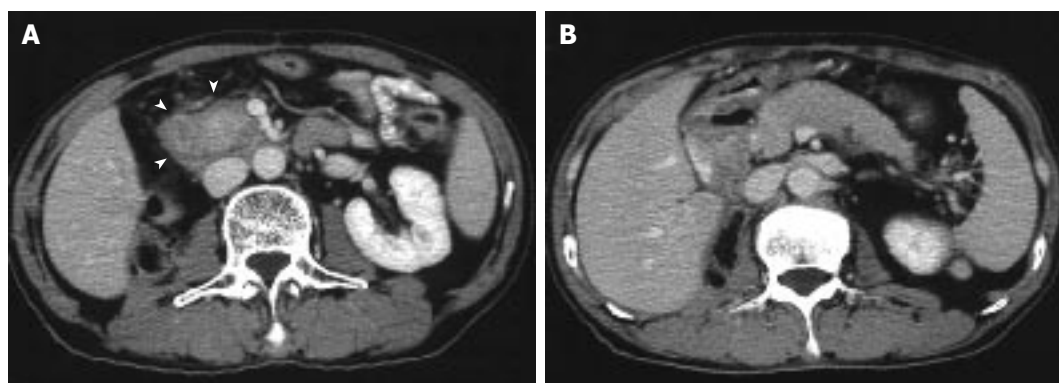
Dynamic computed tomography scan showing swelling of the pancreas head. A capsule-like low-density rim can be seen around the pancreas head (white arrowheads) (A). The pancreas body and tail are swollen (B).
